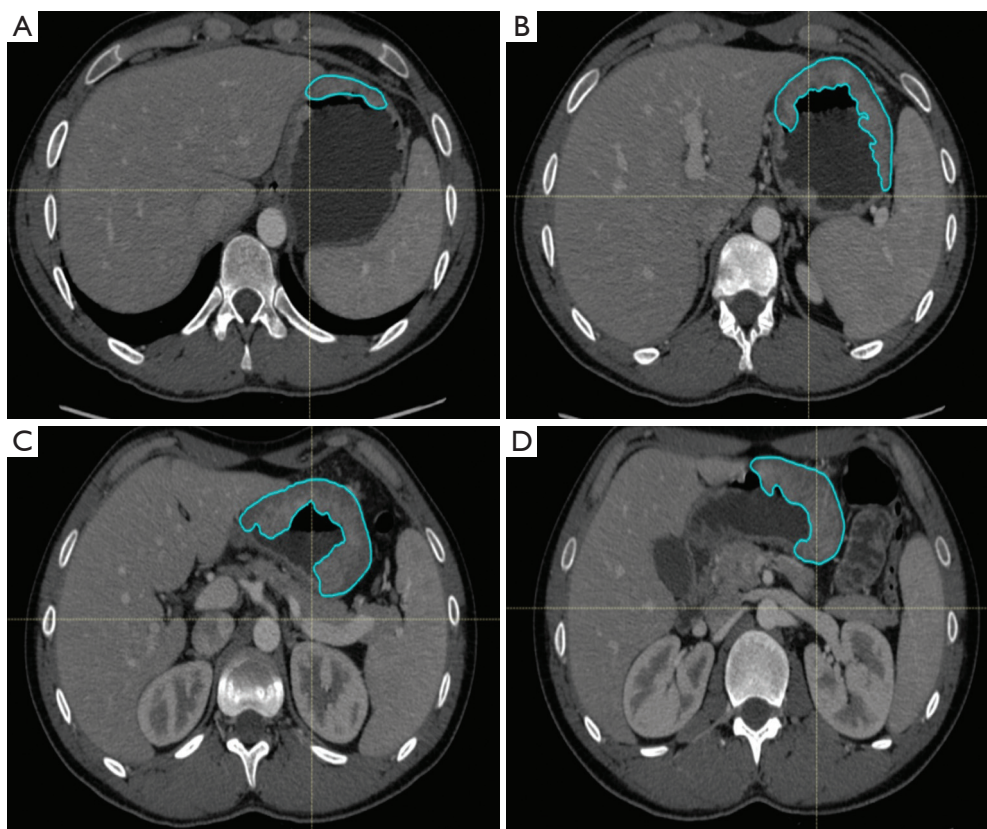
Example of gastric cancer contouring before neoadjuvant chemotherapy. GTV was manually drawn through a ROI on each CT slice (A,B,C,D) and not only where neoplasm was more evident. GTV, gross tumor volume; ROI, region of interest.
